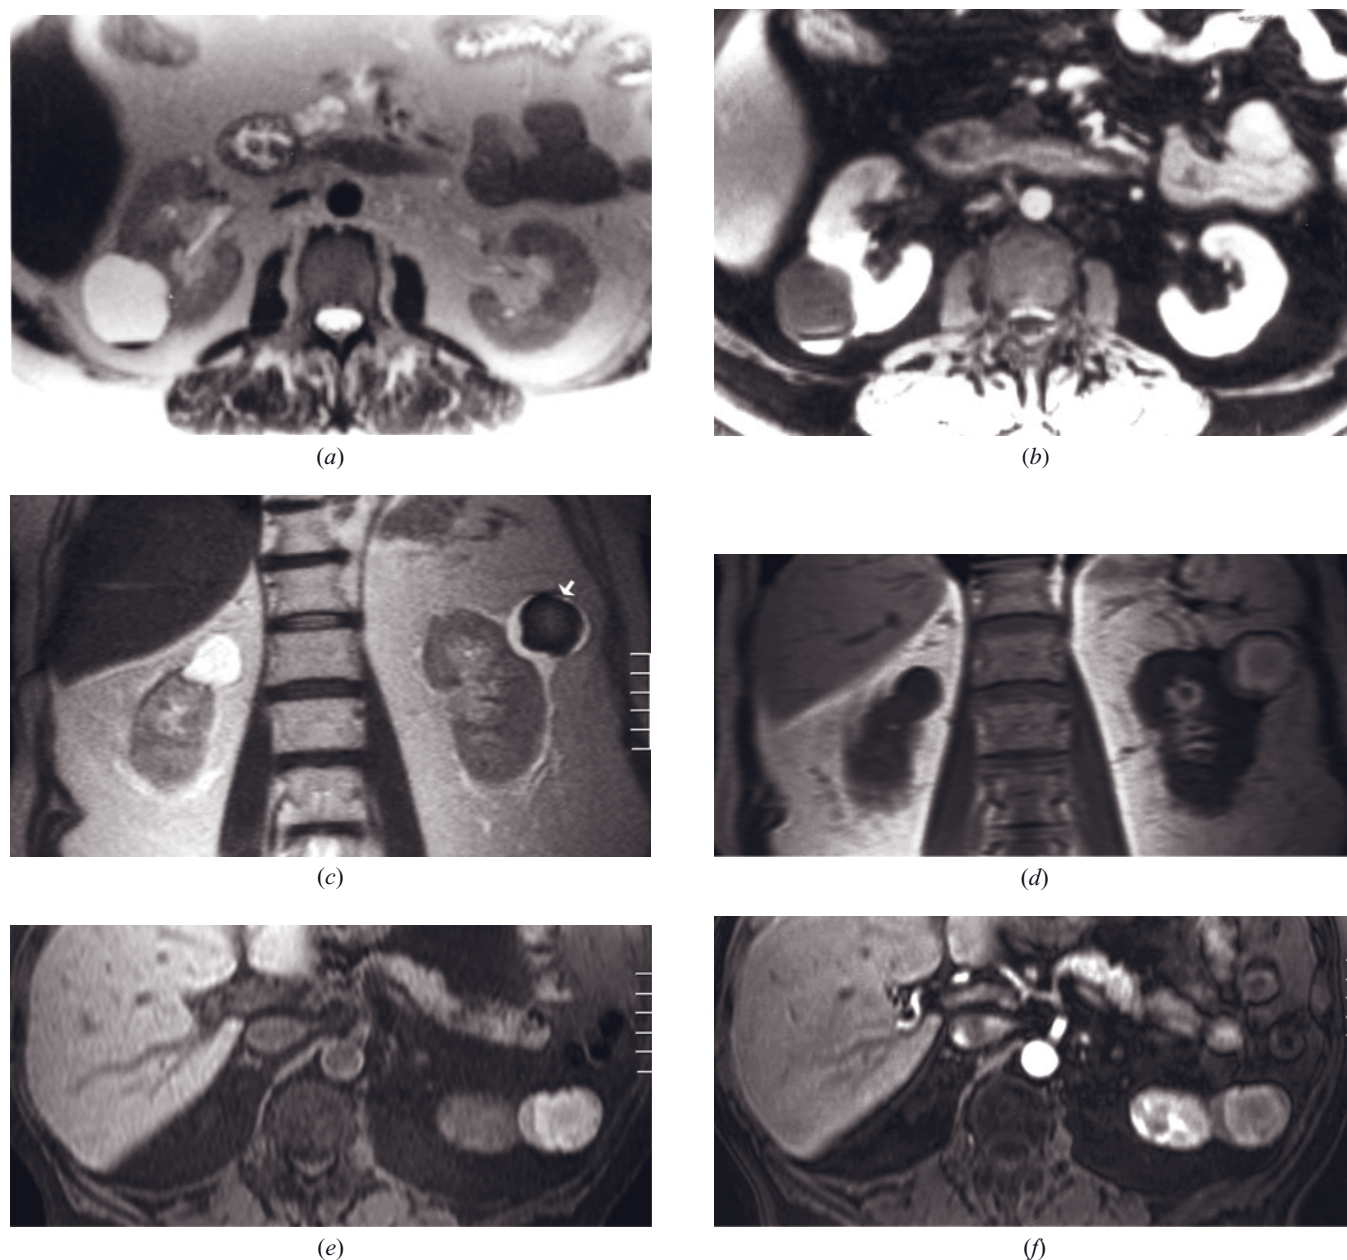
Hemorrhagic cyst. T2-weighted SS-ETSE (a) and T1-weighted fat-suppressed postgadolinium SGE (b) images. A cyst in the right kidney demonstrates layering material that is low signal on T2 (a)- and high signal on T1 (b)-weighted images, consistent with hemorrhage. Coronal T2-weighted SS-ETSE (c) and T1-weighted gradient-echo (d) and transverse T1-weighted fat-suppressed 3D gradient-echo (e) and immediate postgadolinium T1-weighted fat-suppressed 3D gradient-echo (f) images in a second patient with bilateral renal cyst. The cyst in the left kidney exhibits low signal on T2-weighted (c) and high signal on T1-weighted (d, e) images and shows lack of enhancement on early-phase images (f), consistent with acute hemorrhage. In contrast, the cyst in the right kidney shows high signal intensity on T2-weighted images (d) and lack of postcontrast enhancement (not shown) consistent with a simple cyst.
